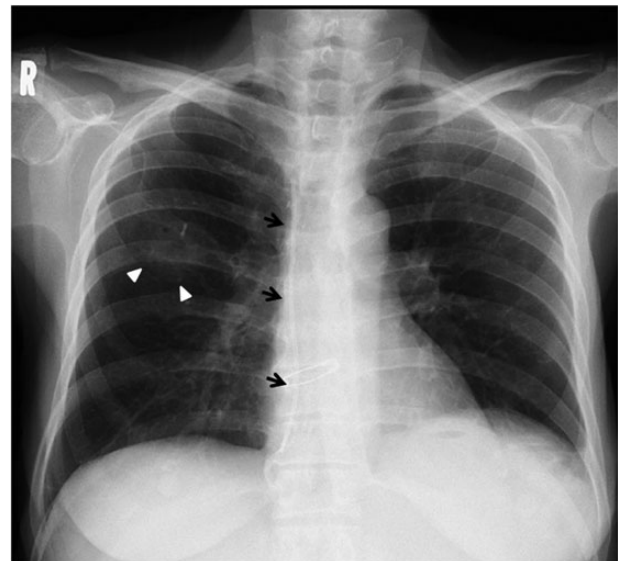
Chest X-ray showing the detached catheter from the port.
